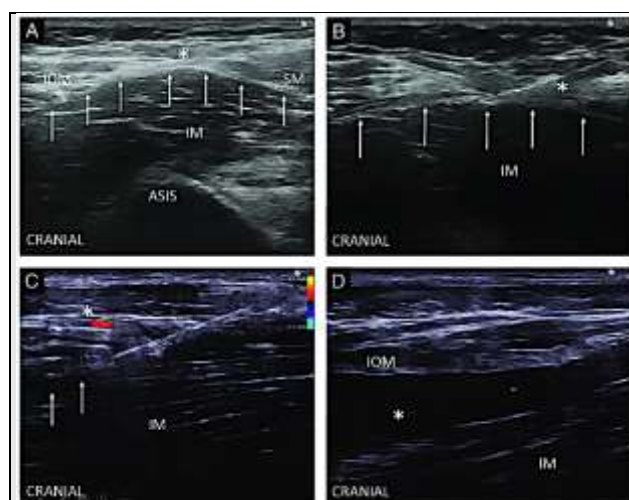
Ultrasound Image of Structures in Longitudinal Suprainguinal FICB
